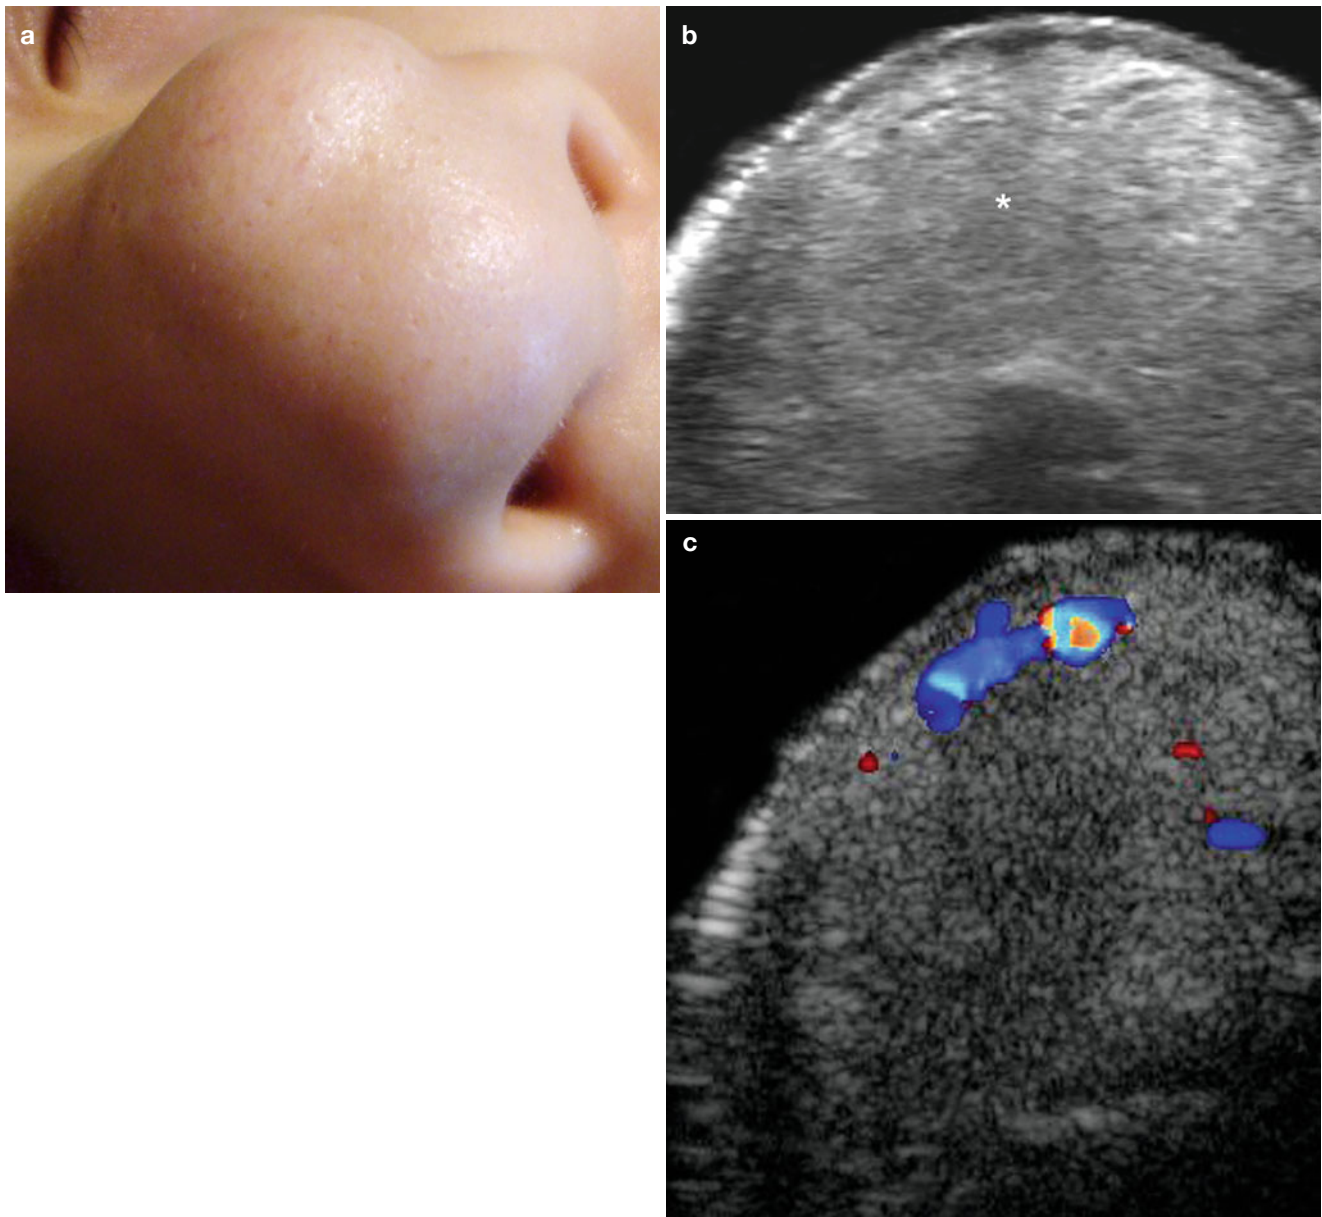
(a–c) Hemangioma (complete regression phase). (a) Clinical image shows a lump in the tip of the nose. (b) Grey scale ultrasound image (transverse axis) demonstrates ill-defined hyperechoic mass (*)
